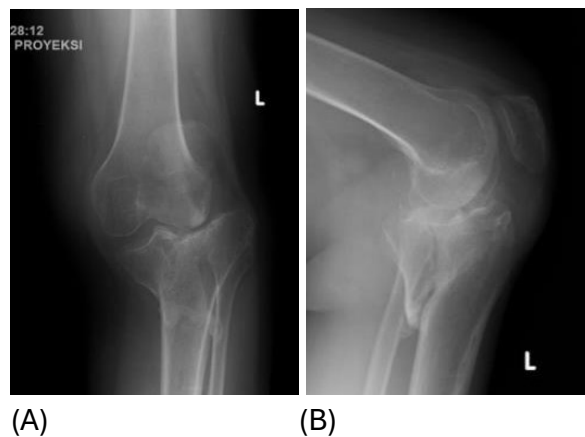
Preoperative anteroposterior (Fig. 1-A) and lateral (Fig. 1-B) radiograph of the left knee. There is a slight defect on the lateral plateau and depression on the medial plateau.
